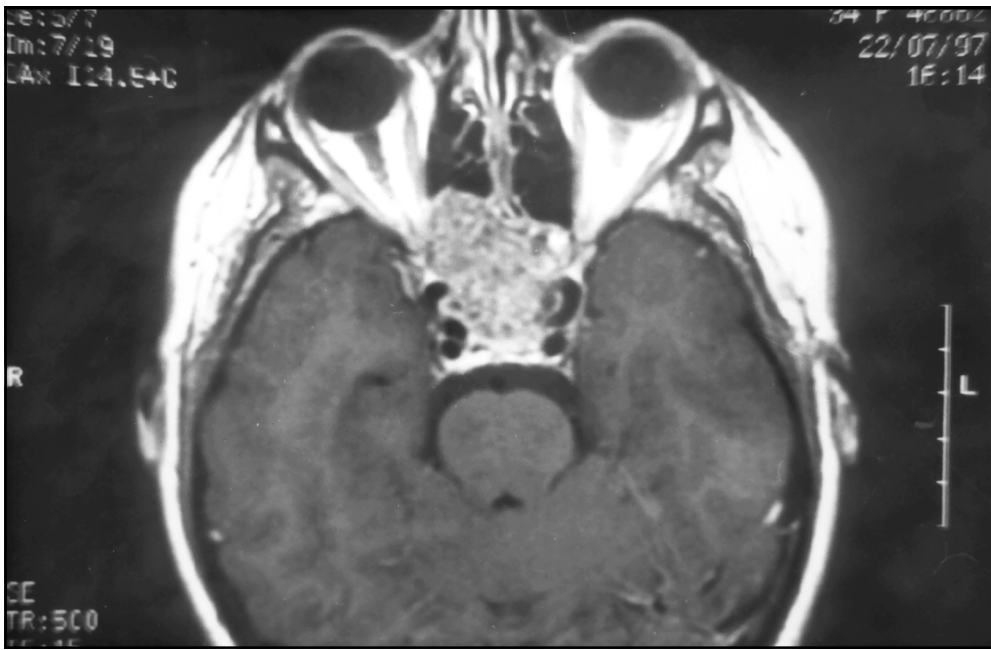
T1-weighted gadolinium enhanced axial MRI scans, showing a heterogeneous enhancing sphenoid sinus mass with extension into the ethmoid sinus.
